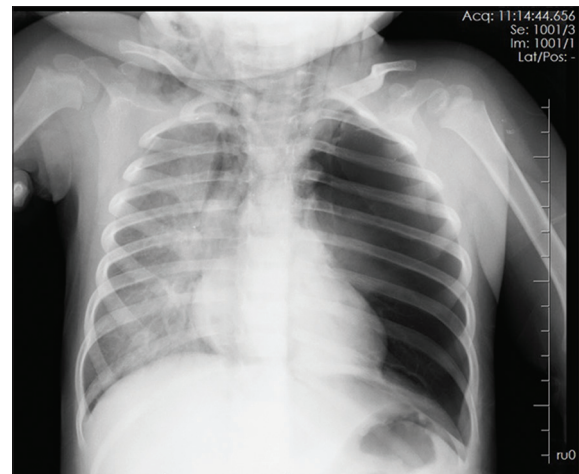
After iatrogenic tracheal rupture, the chest radiograph that revealed pneumomediastinum and left pneumothorax
